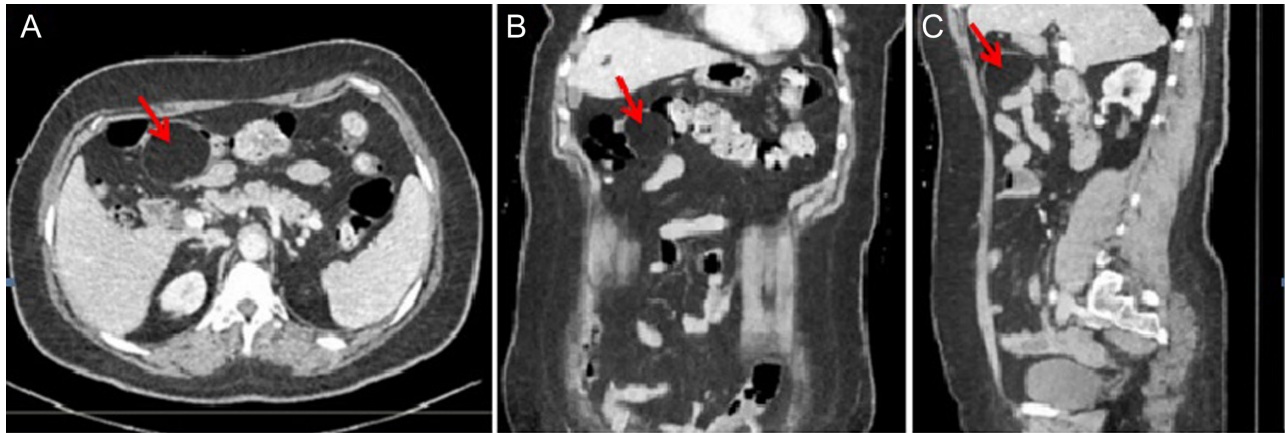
Preoperative axial (A), coronal (B), and sagittal (C) computed tomography scans of abdomen revealed a round mass within the lumen of the transverse colon, densitometric values were consistent with a homogeneous fatty lesion causing colonic obstruction (red arrows).
